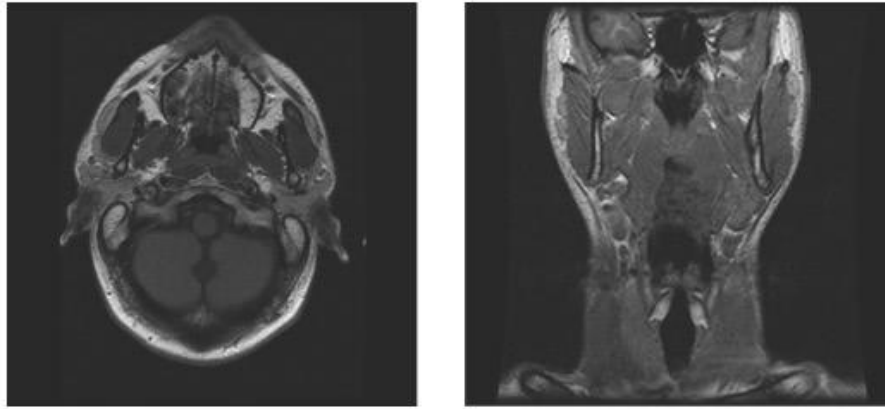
Images from the MRI scanner allowing the identification of the masseter muscle limits and fibres orientation.
